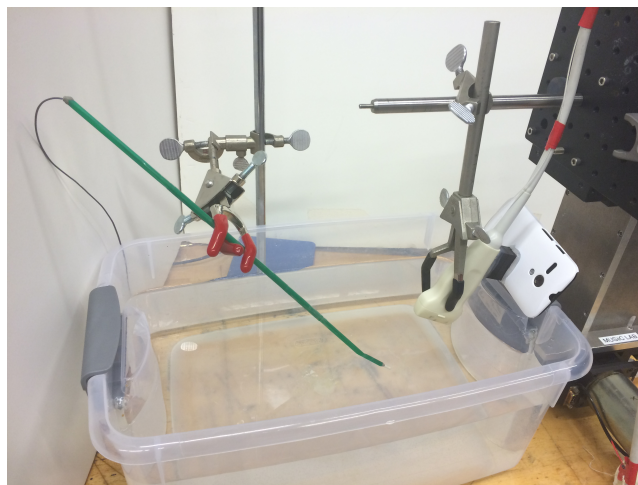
The experimental setup used to validate this sensor fusion needle tracking approach. An ultrasound transducer with an attached camera is held by a Cartesian stage as it observes a piezoelectric element.
